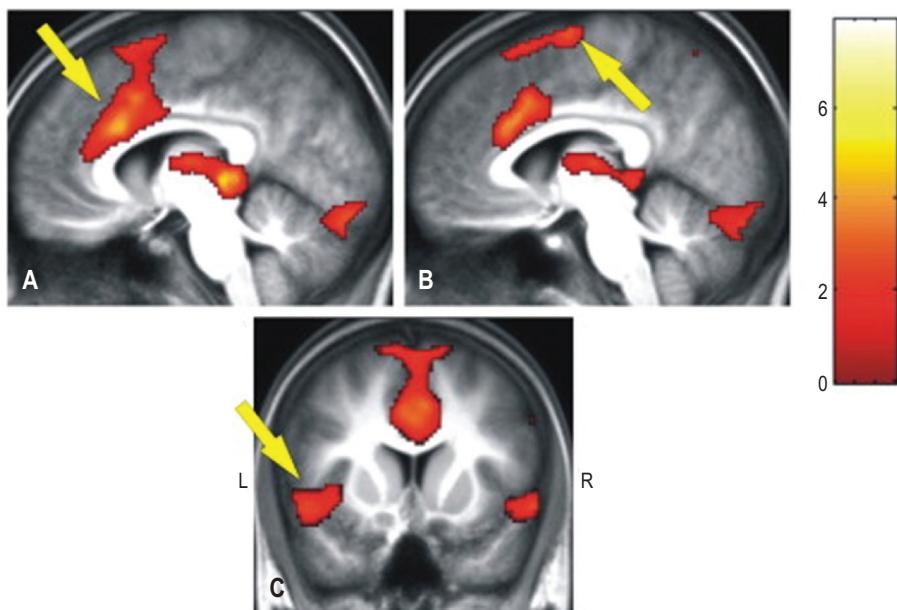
BOLD MRI activation maps. Patients with arachnophobia show much stronger signals compared with the controls in (A) the anterior cingulate cortex, (B) the supplementary motor cortex and (C) the insula for the contrast 'Spider > Neutral' (colour bar indicates the t-value) (From Goossens et al., 2007.)
